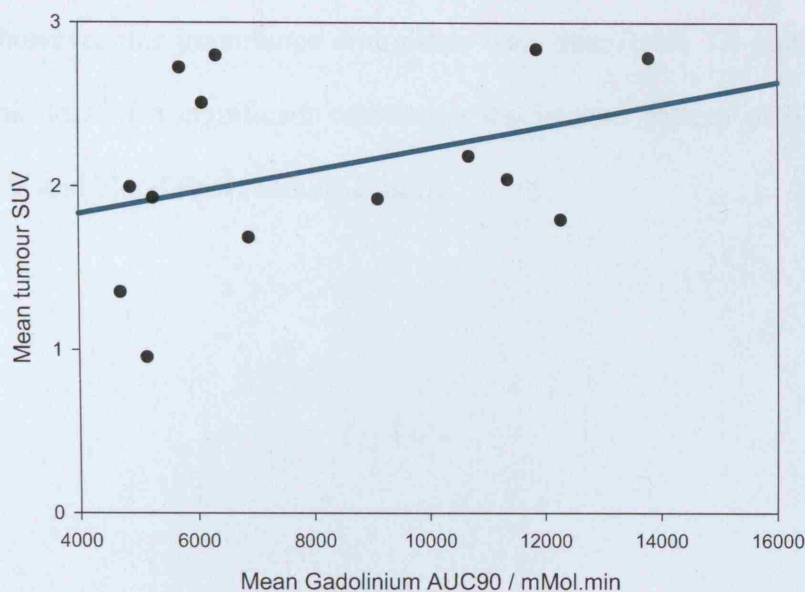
Plot to evaluate the relationship between mean tumour SUV and AUC90 which is not statistically significant. The regression line is green (n=14).
